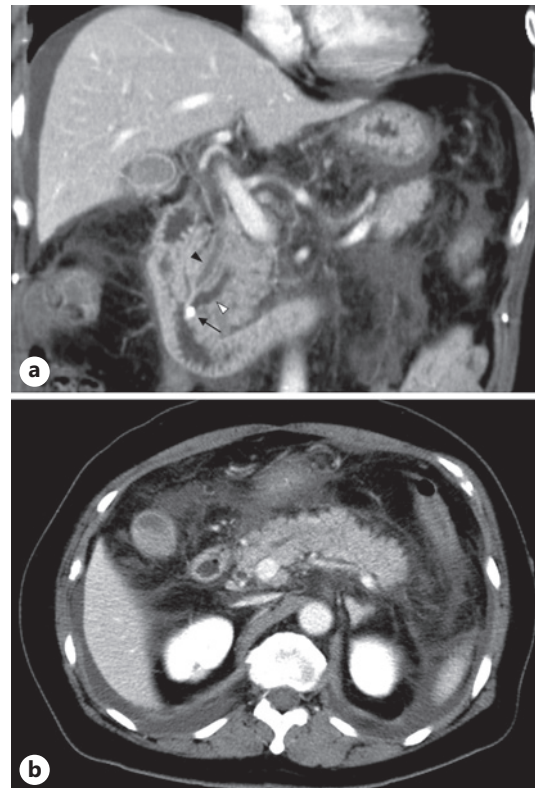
Contrast-enhanced CT images obtained in the evening on post-admission day 1. a Coronal view. b Axial view. a A calcified stone (arrow) measuring 6 mm is observed in the MPD with upstream dilation (white arrowhead). No dilation of the common bile duct is observed (black arrowhead). b Diffuse swelling of the pancreas and peripancreatic inflammation are observed.
